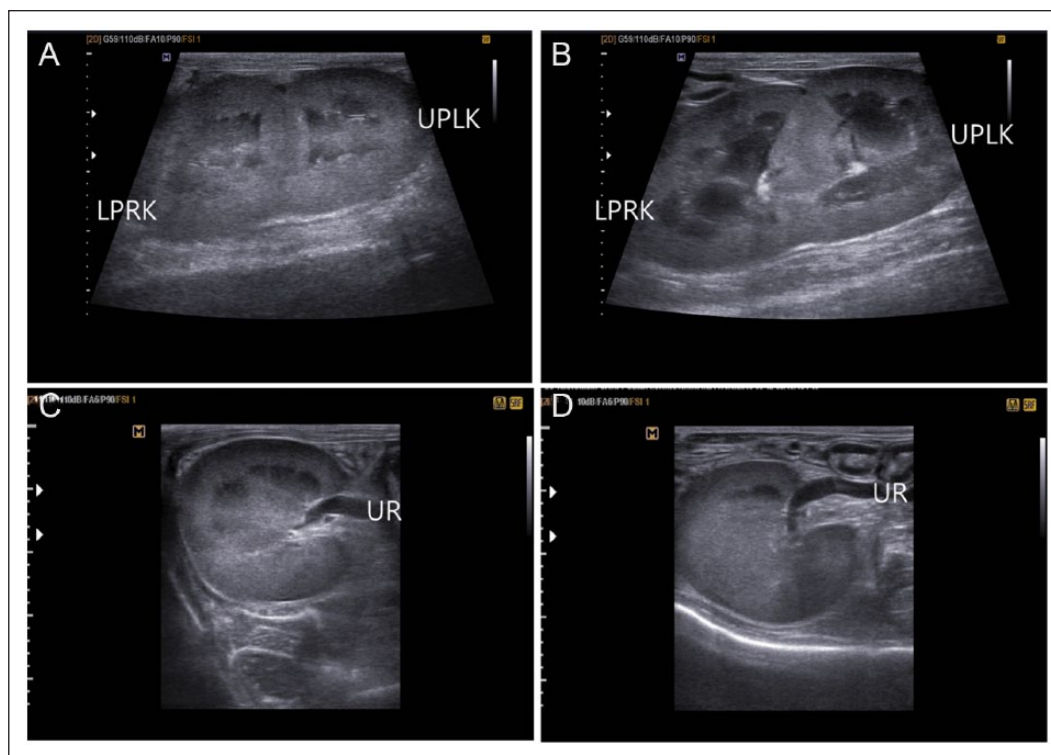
Ultrasonographic longitudinal images of kidneys in this case. (a,b) Ultrasonography showing the upper pole of the left kidney and the lower pole of the right kidney fused with each other. (c,d) The proximal portion of ureters in both kidneys were dilated. LPRK = lower pole of right kidney; UPLK = upper pole of left kidney; UR = ureter.
